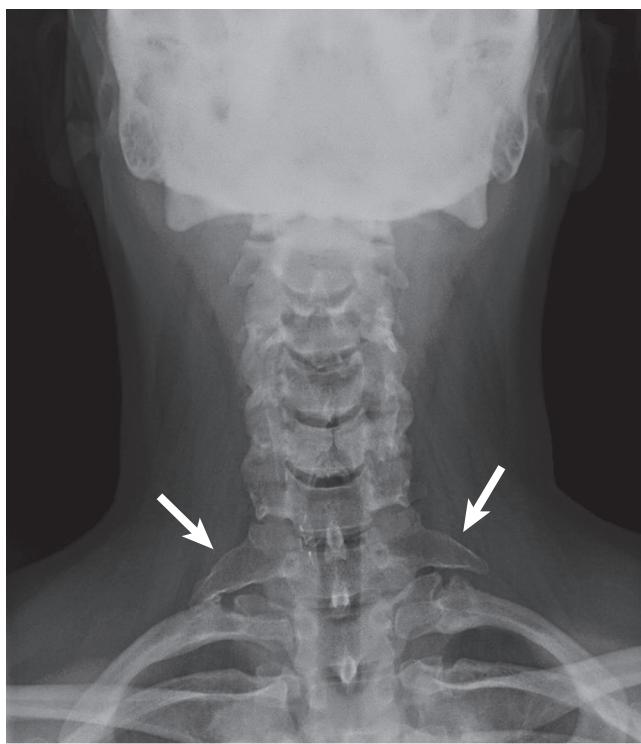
Chest radiograph demonstrating bilateral cervical ribs (arrows) in a patient with arterial thoracic outlet syndrome.
